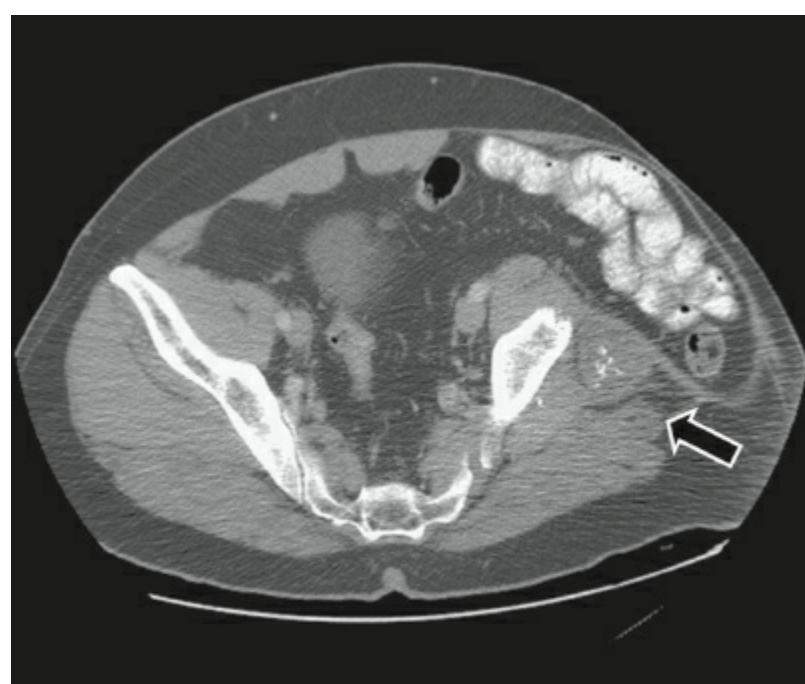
Chondrosarcoma recurrence. A 60-year-old man had previously undergone resection of a low-grade chondrosarcoma of the left pelvis, necessitating resection of the left iliac bone. After many local bony recurrences, he was found to have an extraskeletal site of disease. On the CT scan, adjacent to the remaining bone, there is a 4.4- × 3.6-cm soft tissue mass (arrow), which contains dystrophic calcifications. Recurrent disease was completely resected.
